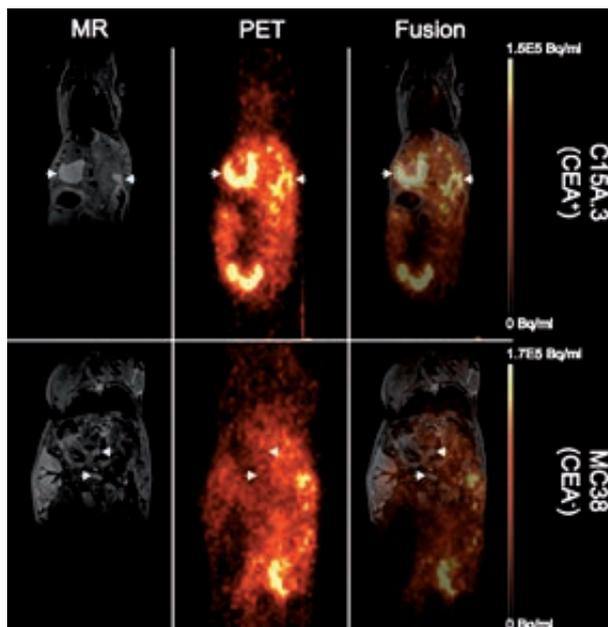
MR images clearly show the location of the liver metastases (arrows). Immuno-PET images indicate strong signals in the areas of the CEA-positive C15A.3-derived liver metastases (top). No enhanced ^{64}Cu DOTA-antibody uptake was observed in the areas of CEA-negative MC38-derived metastases (bottom).
